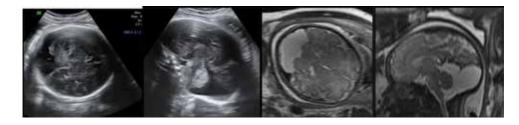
Isolated mega cisterna magna. US and MRI images of the same third-trimester case.
